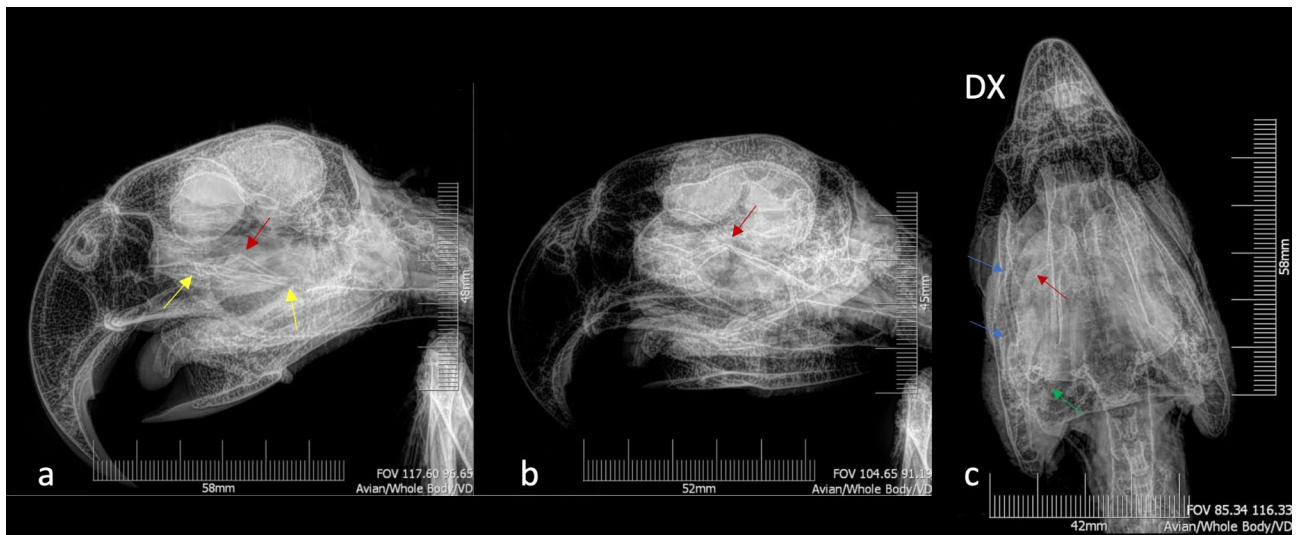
Radiographic right latero-lateral view of (a) the pterygoid bone fracture (red arrow) and jugal arch fractures (yellow arrows). Left dorsal/right ventral lateral oblique view of (b) the fracture of the right pterygoid bone (red arrow). Ventro-dorsal view of (c) the fractures of the pterygoid bone (red arrow) and the right jugal arch (blue arrows) and medial luxation of the right quadrate bone (green arrow)
